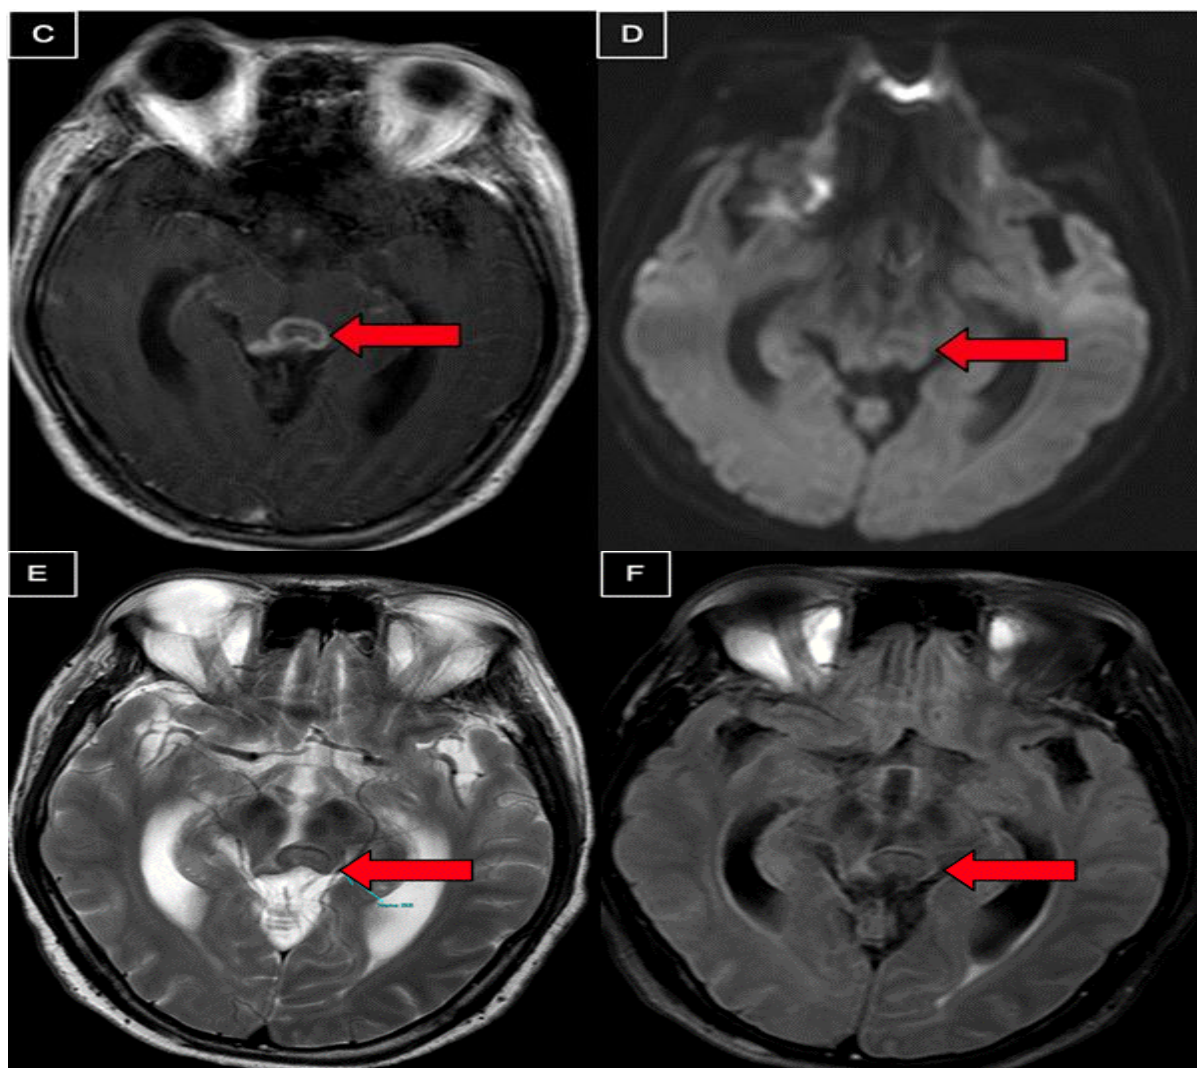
MRI Brain with gadolinium contrast A.Sagittal B.Coronal T1 view with 1.5 cm lesion with peripheral enhancement and hypointense centre hyperdensity. C.Axial T1 view with a ring component and nodular component from the right posterior region. D.Diffusion weighted image with restricted diffusion in the periphery with no enhancement of the central region. E.Axial T2 view with hypointense lesion with peripheral hypointense rim. F.Axial FLAIR view with transependymal edema in the posterior horn of the left lateral ventricle.
